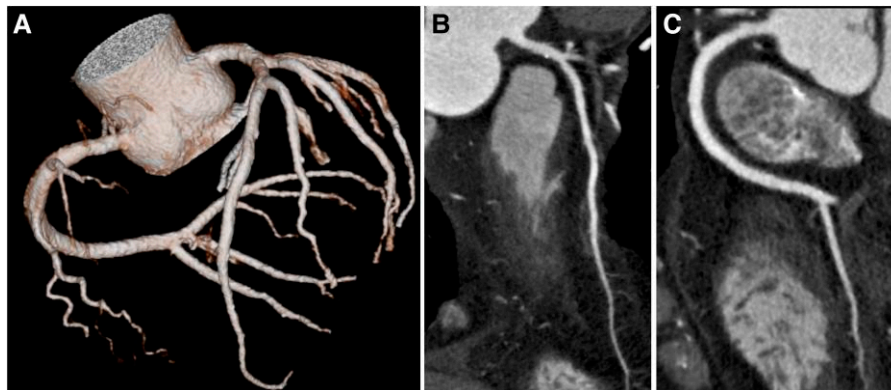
Coronary computed tomographic angiography. Three-dimensional volume-rendered image of the left and right coronary arteries (A) and curved multi-planar reconstruction images of the left main trunk to the left anterior descending coronary artery (B) and the right coronary artery (C) show no luminal narrowing.
